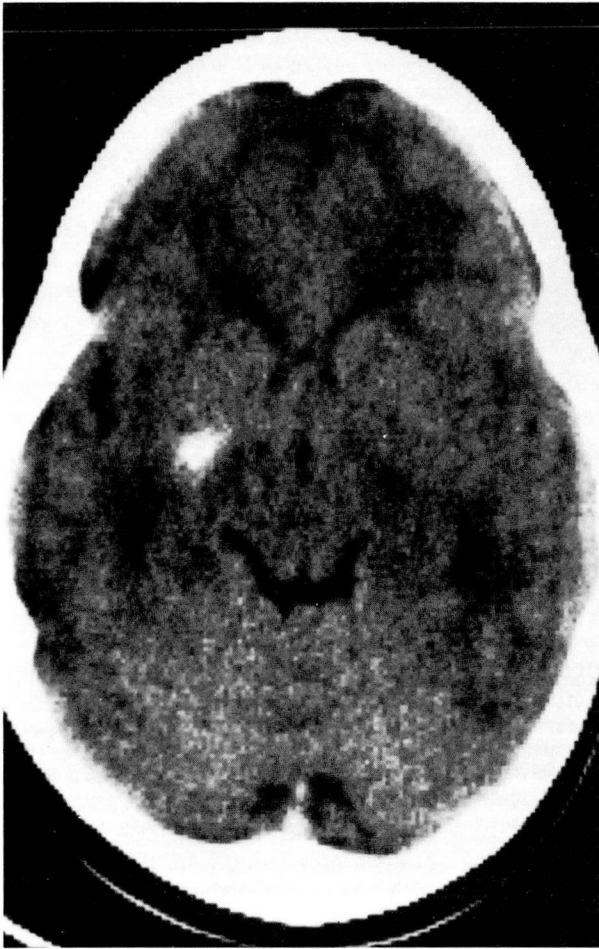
CT scan without contrast of a 21-month-old baby with CPS, showing a calcified lesion in the right anterior temporal region (sides are reversed on this film). The infant's ictal EEG is reproduced in Figure 4. The patient had CPS with staring and a frightened look, up to two or three per day, from the age of 3 months.
